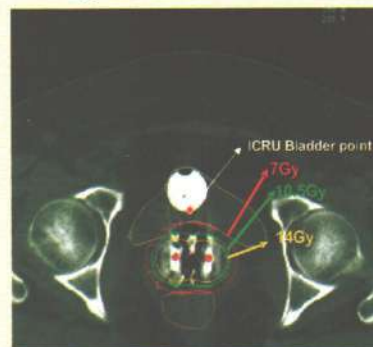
Figure showing the CT scan based 3D image with dose ICRT distribution. The bladder point is actually getting less dose, while the actual bladder wall which is better visualized on CT scan is getting high dose. So the 2D x ray based system actually creating false impression of safe dose to bladder when actually its receiving very high dose
